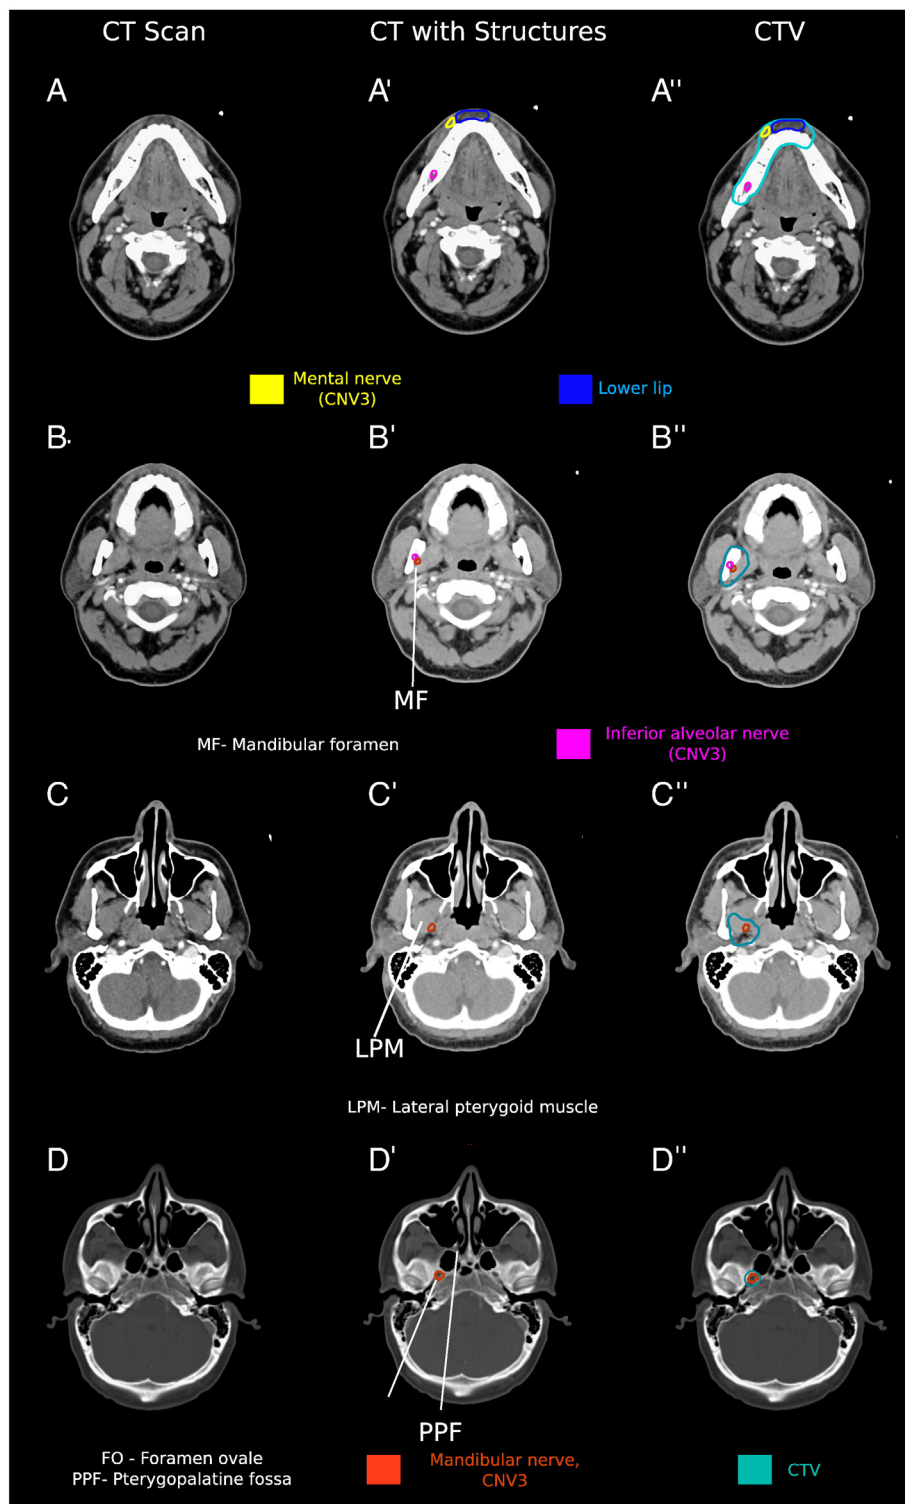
Axial computed tomographic (CT) slices of the lower lip and related cranial nerves. The left column (A-D) depicts axial CT images of the area of interest, the middle column (A'-D') depicts the nerves contoured on CT images, and the right (A''-D'') depicts these contours with a clinical target volume (CTV; shown in teal). The mandibular nerve (cranial nerve [CN] V₃) (shown in orange), and its branches, the inferior alveolar nerve (shown in purple) and the mental nerve (shown in yellow), provide innervation to the lower lip (shown in blue), and are at risk for harboring cancer in the setting of perineural invasion.
